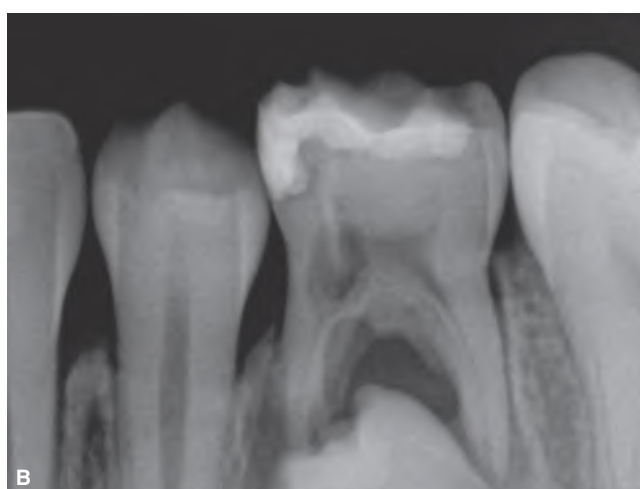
A. Bitewing radiograph showing internal resorption and an interdicular radiolucent area associated with the primary mandibular left second molar. B. Periapical radiograph of the same tooth. Note the large interdicular radiolucent area and the displaced permanent successor tooth.
